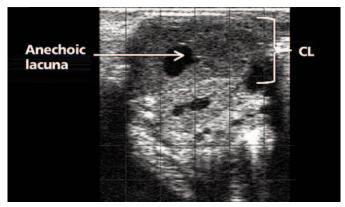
Ultrasound image of a corpus luteum (CL) with anechoic lacuna. CL appears as a grey, circular structure (brackets) and anechoic lacuna as a black, circular structure in the middle (arrow). Image obtained using BCF Easi-Scan.
